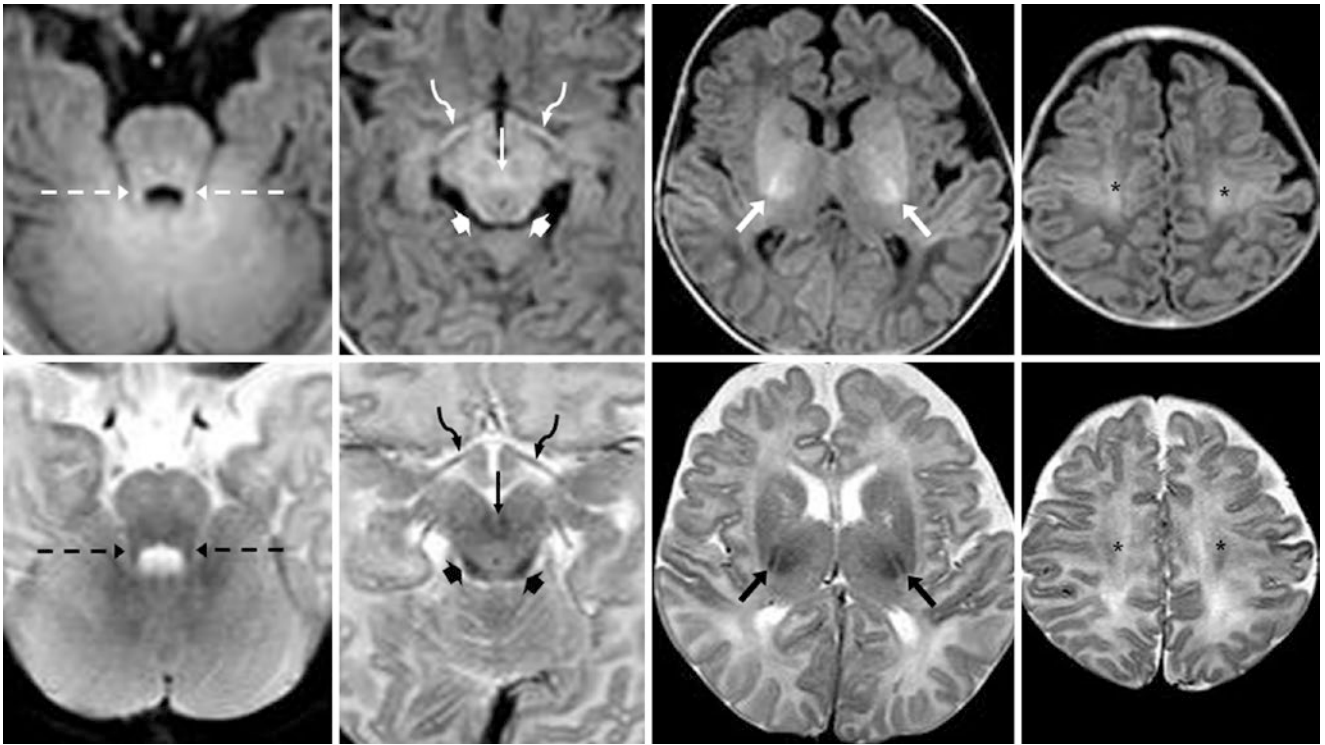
A 5-week-old with fevers and a negative 1.5T MRI. GE T1WIs (*top row*) show myelinated superior cerebellar peduncles (*dashed arrows*), optic tracts (*curved arrows*), PLICs (*arrows*), and centrum semiovale (*asterisks*), which are present but less visible on SE
